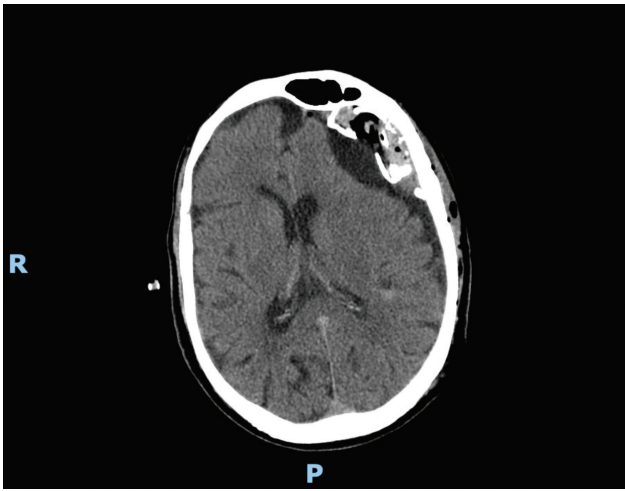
Computed tomography scan performed after the second surgical procedure showing a decreased hematoma volume, as well as the communication of the calcified capsule with the subdural space. Abbreviations: R, right; P, posterior.
